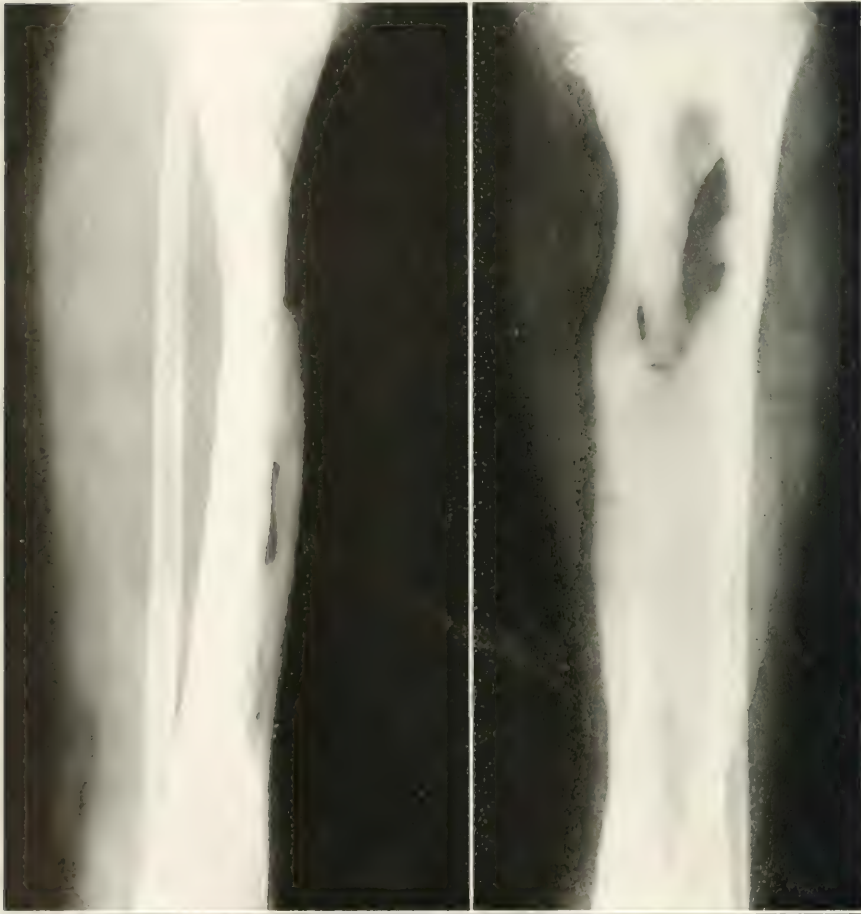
(Case 2).—Roentgenogram taken, Oct. 18, 1920; new bone formation around healed patient walking on leg; feels well.
